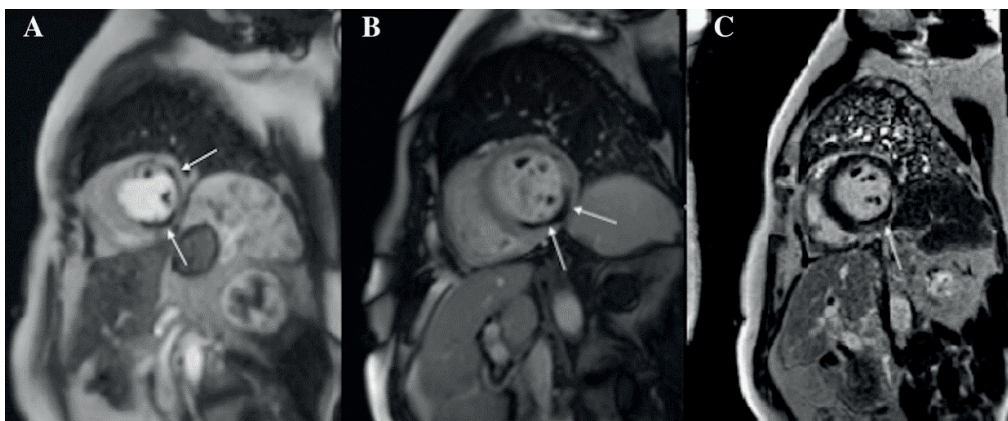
Cardiac magnetic resonance imaging. Arrows indicate microvascular obstruction (areas of hypoenhancement) visible on first-pass perfusion (A), early gadolinium enhancement (B), and late gadolinium enhancement (C).
